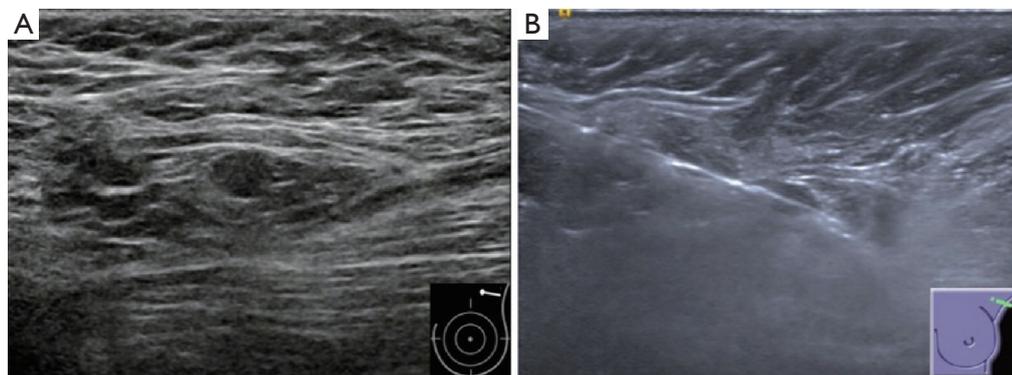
Invasive ductal carcinoma in a 73-year-old woman with a negative result of axillary lymph node CNB but two lymph nodes metastases after surgery. (A) Gray-scale US image of the ipsilateral axilla shows a small (0.7×0.5 cm) suspicious lymph node with an absent fatty hilum. (B) US image obtained post-firing of CNB shows that the needle passes the lymph node precisely, but the visualization of needle may be caused by the artifact from partial volume effects. CNB, core needle biopsy; US, ultrasound.
